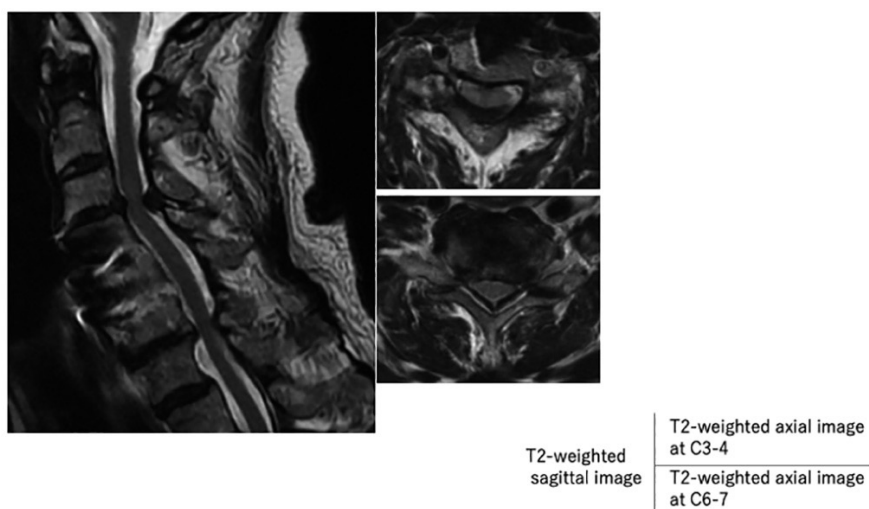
MRI studies at 4 years after the initial ACDF at C4-5. Reflecting the development of spastic limb paresis, the MRIs showed marked cord compression with high-intensity T2 signals within the cord at C3-4 adjacent to the previous ACDF level.
